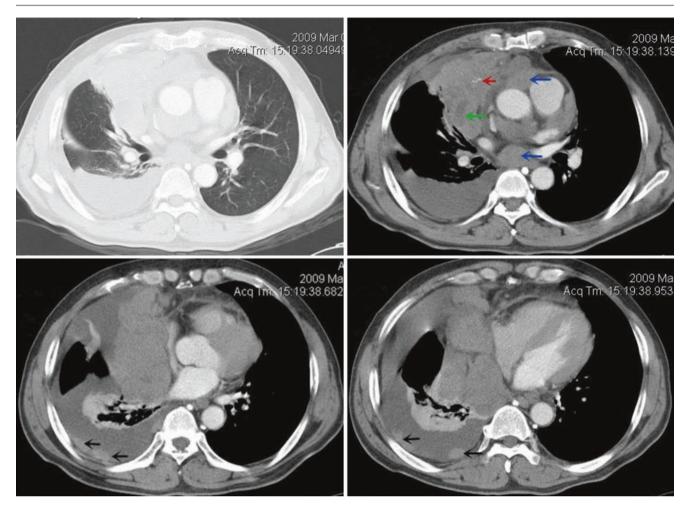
Chest CT images of a 50-year-old man complained of cough and chest tightness for 4 months
